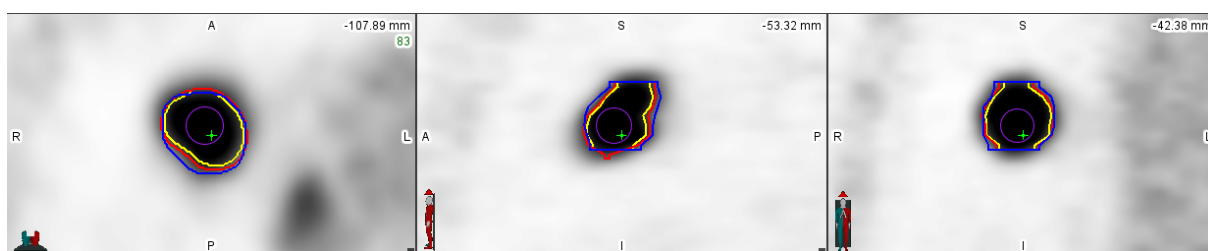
Axial, coronal and sagittal slices showing a lung lesion segmented using the gradient-based algorithm (blue), 41 % threshold (red) and 50 % threshold (yellow). The location of the  $SUV_{max}$  is denoted by the green cross and the  $SUV_{peak}$  volume by the purple sphere.
